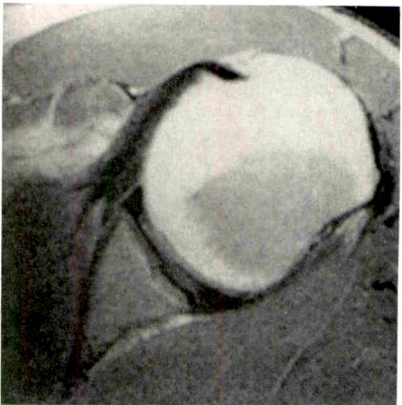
Increased intralabral signal. Axial proton density-weighted image through mid glenoid fossa shows faintly increased signal in substance of anterior part of labrum. This could not be confirmed on T2-weighted image, which showed homogeneously low signal. Finding is presumed similar to changes encountered in menisci of knee, most likely representing some degree of intrasubstance degeneration or increased water content.
